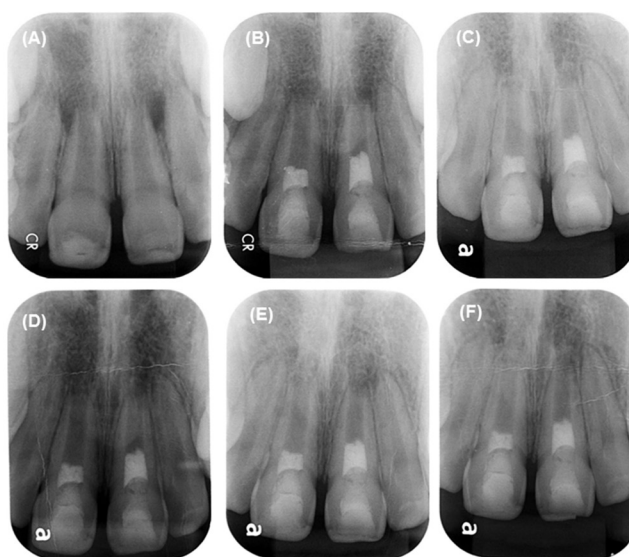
Representative periapical radiograph images of complete healing and cervical sealing adequacy after a two-year-follow-up. This case involved an 8-year-old male who traumatized the right and the left central maxillary incisors after a fall (causing enamel-dentin-fracture associated with extrusive luxation). (A) Preoperative radiograph showing periapical radiolucency. The patient had not reported clinical symptoms. (B) Postoperative radiograph after pulp revascularization. (C) Three-month-follow-up. (D) Six-month-follow-up. (E) Twelve-month-follow-up. (F) Twenty-four-month-follow-up showing an absence of apical closure and an absence of continued root development
